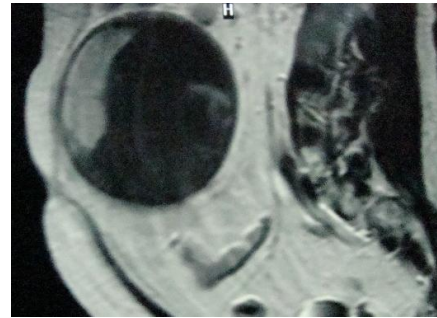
CT Scan-sagittal plane
